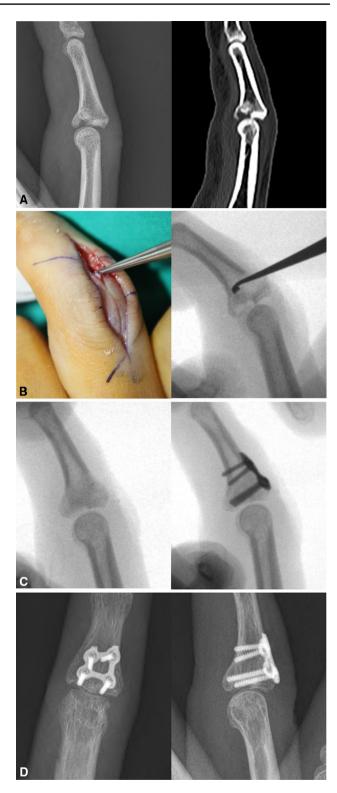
Representative case of transosseous reduction and dorsal locking plate fixation. a Preoperative radiograph and CT scan showing a volar lip fracture with a depressed intraarticular fragment. b Cortical window creation on the dorsal bare area of the middle phalanx, and reduction of the impacted fragment using a microcurette inserted through the window. c Locking plate positioning after reduction and insertion of the most proximal screw to buttress the articular fragment. d Postoperative radiographs at 6 weeks
